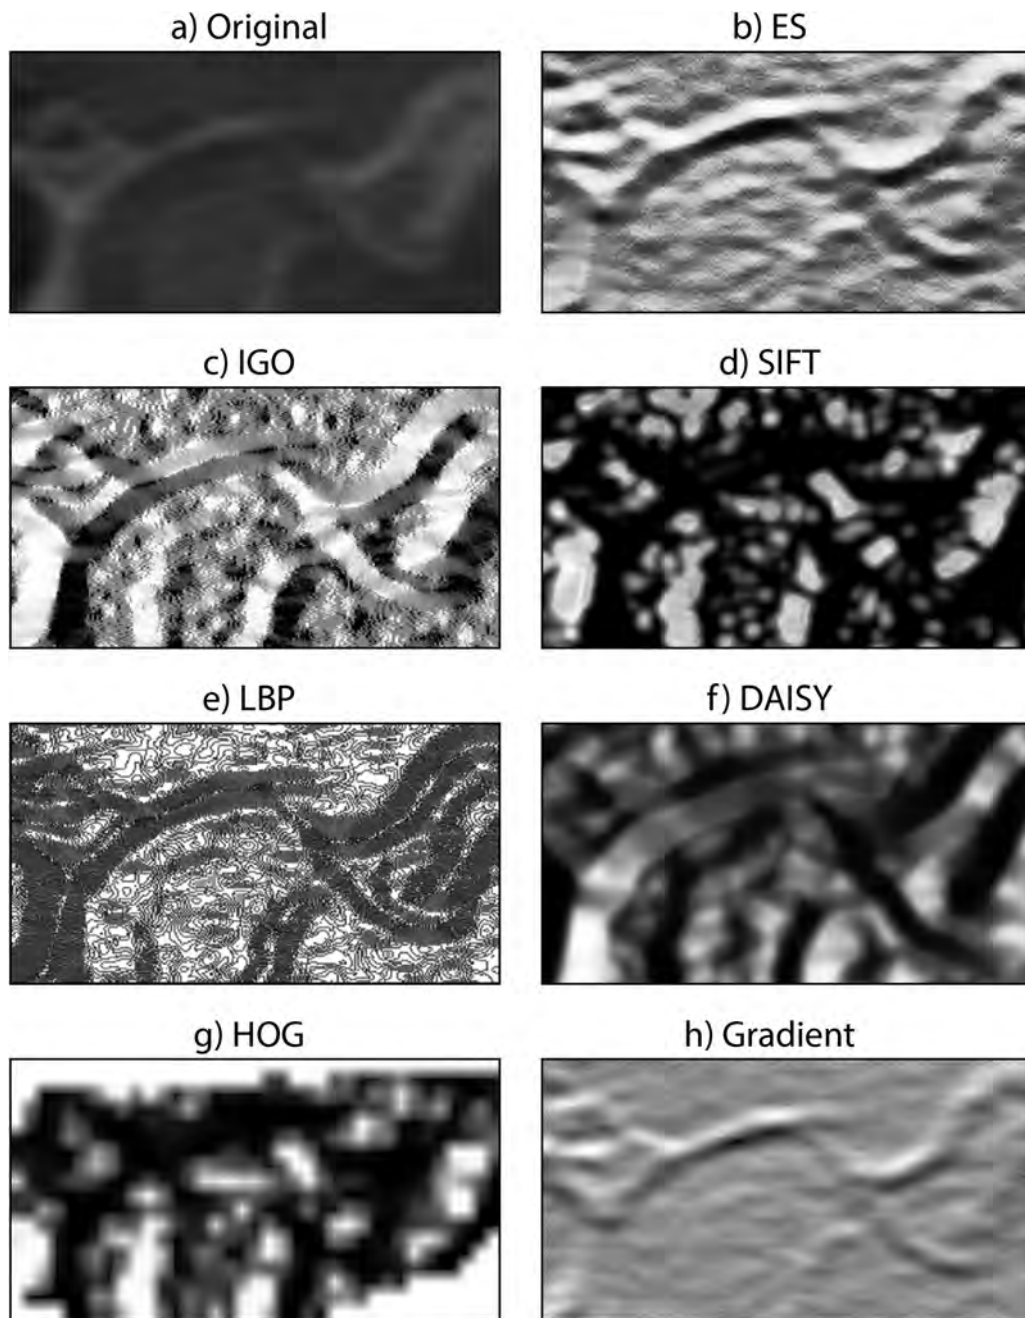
(a) Patch of an original panoramic radiograph used as a template image to show the results of application of the following highly-descriptive, dense appearance features: (b) edge structures; (c) image gradient orientation kernel; (d) scale-invariant feature transform; (f) DAISY; (g) histograms of oriented gradients; (h) contour gradients.
